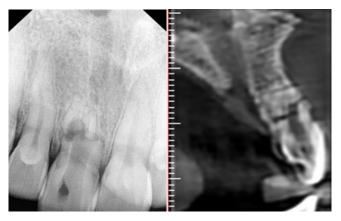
Peri apical radiography and Cone Beam Computed Tomography (CBCT) for one of the patients had history of dental trauma to upper right central incisor when he was a child.
